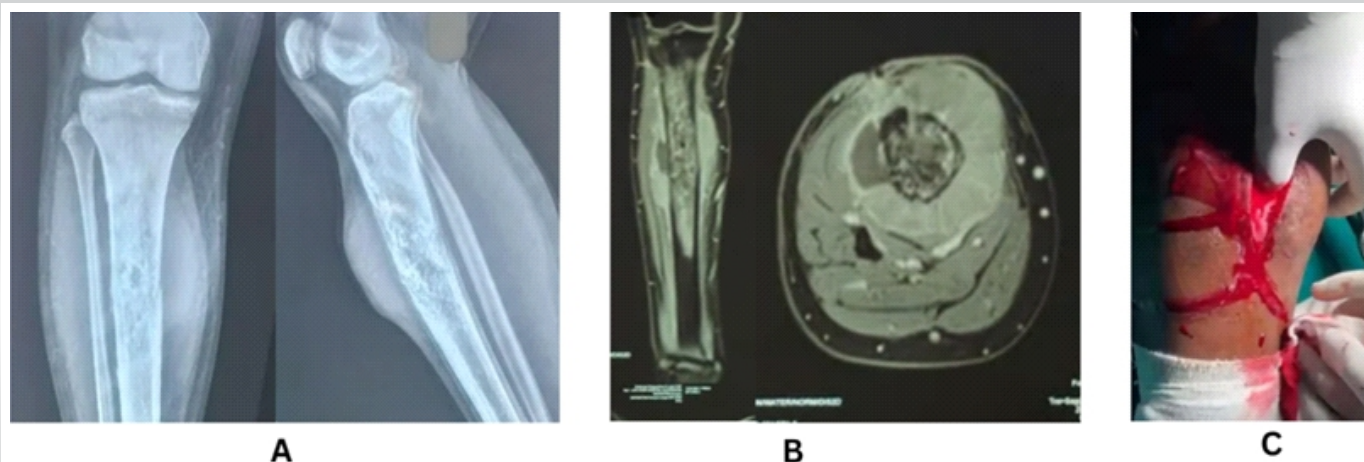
(a) X-ray showing a destructive permeative lesion in the proximal shaft of the right tibia with features suggestive of malignancy, (b) magnetic resonance imaging demonstrating permeative lytic lesion with cortical erosions, periosteal reaction, and associated soft-tissue component in the proximal right tibia, (c) Intraoperative image showing pus-like discharge obtained during open biopsy of the tibial lesion.
